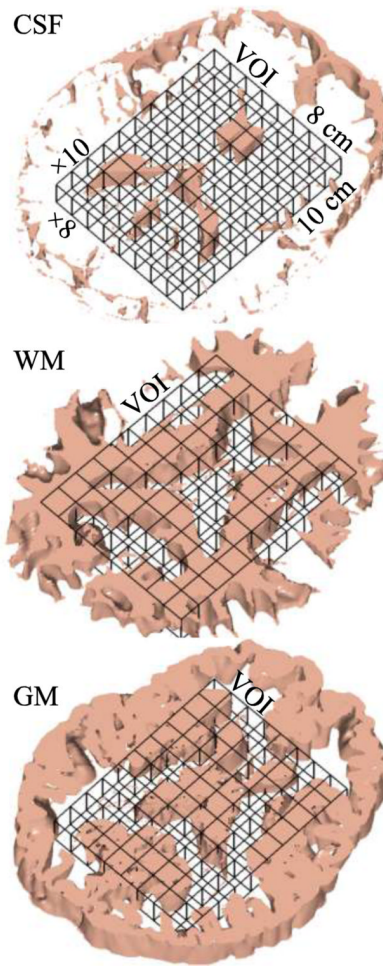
^1H -MRS - MRI co-registration
